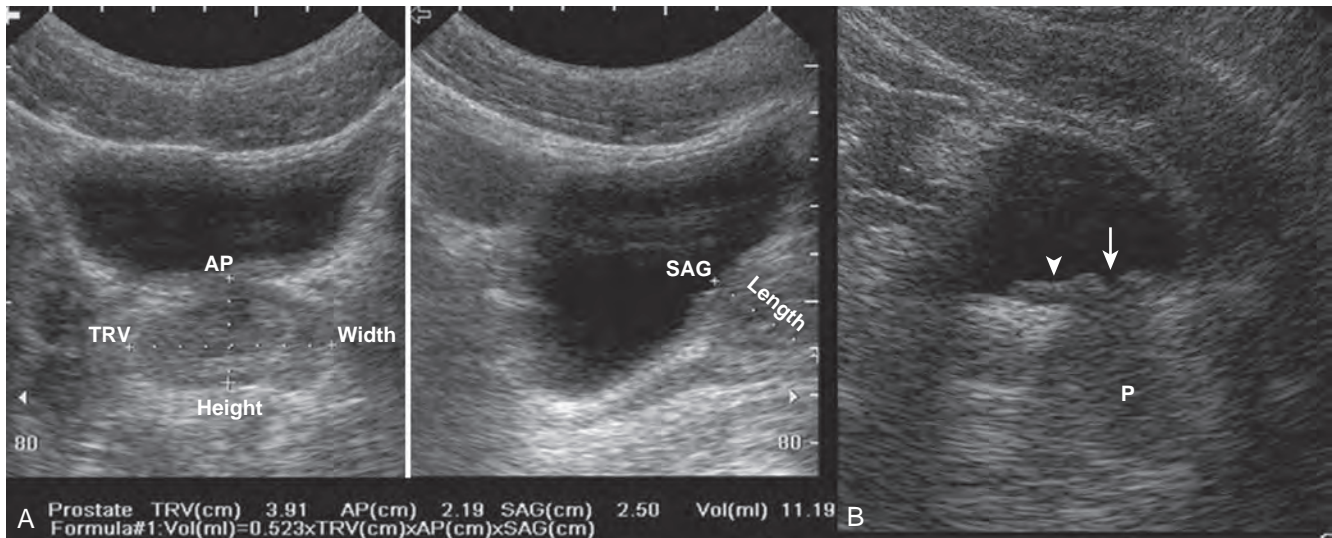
A, Transabdominal ultrasonography is extremely useful for measuring prostatic volume and evaluating prostatic morphology. The volume of the prostate can be calculated using the formula: prostate volume (mL) = width (cm) × height (cm) × length (cm) × 0.523. B, In this midsagittal view of the prostate (P), the bladder neck is identified as a V-shaped indentation (arrow). Note the characteristically hyperechoic trigone (arrowhead).
